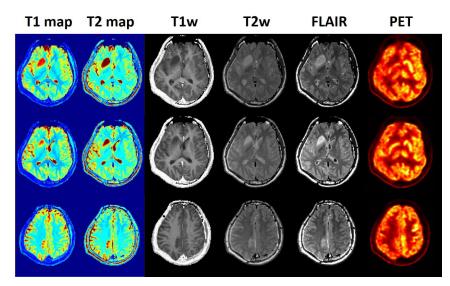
MRF-PET. Three representative slices are shown from a 30-slice whole-brain axial image set obtained after surgery in a patient with a brain tumor. The diverse information obtained from a single continuous six-minute MRF-PET acquisition includes quantitative T1 and T2 maps, jointly reconstructed PET images, and a variety of synthesized contrast weightings, including T1, T2, and FLAIR weightings.
